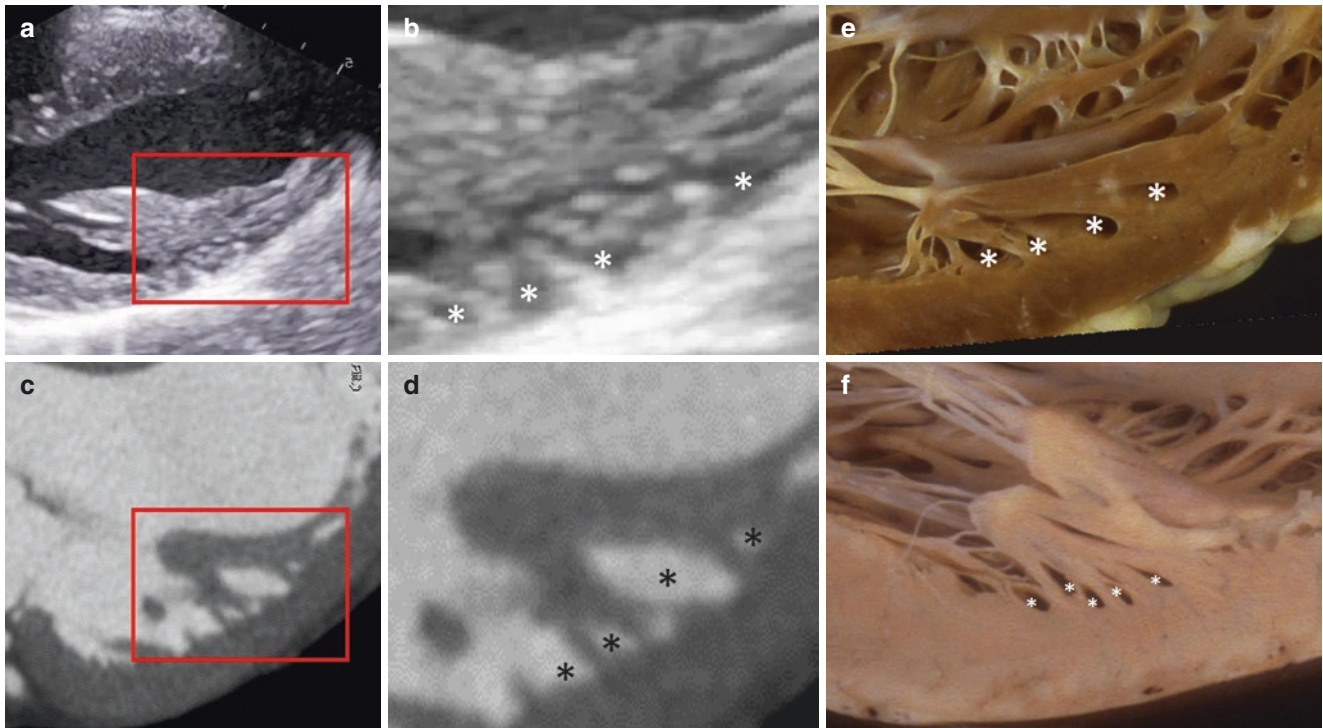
(a) Detail of papillary muscle visualized with 2D echocardiography (a) and CT multiplanar reconstruction (c). The areas in the red box are magnified in (b) and (d) respectively. Images clearly show as the base of papillary muscle attached to the trabeculations rather than
